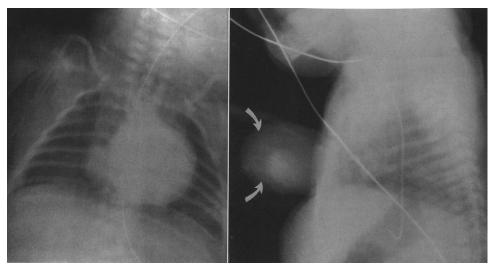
X-rays from a 2-day-old male infant with ectopia cordis. The external position of the heart is obvious in the lateral projection (*right, arrows*) but not in the frontal plain (*left*). Reproduced with permission from Perloff JK. *The Clinical Recognition of Congenital Heart Disease*. 5th ed. Philadelphia, Pennsylvania: W.B. Saunders, 2003.
